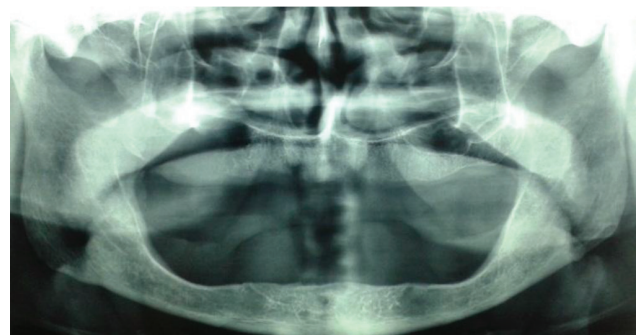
Panoramic view of a radiograph showing destruction of the floor of the right maxillary sinus.
